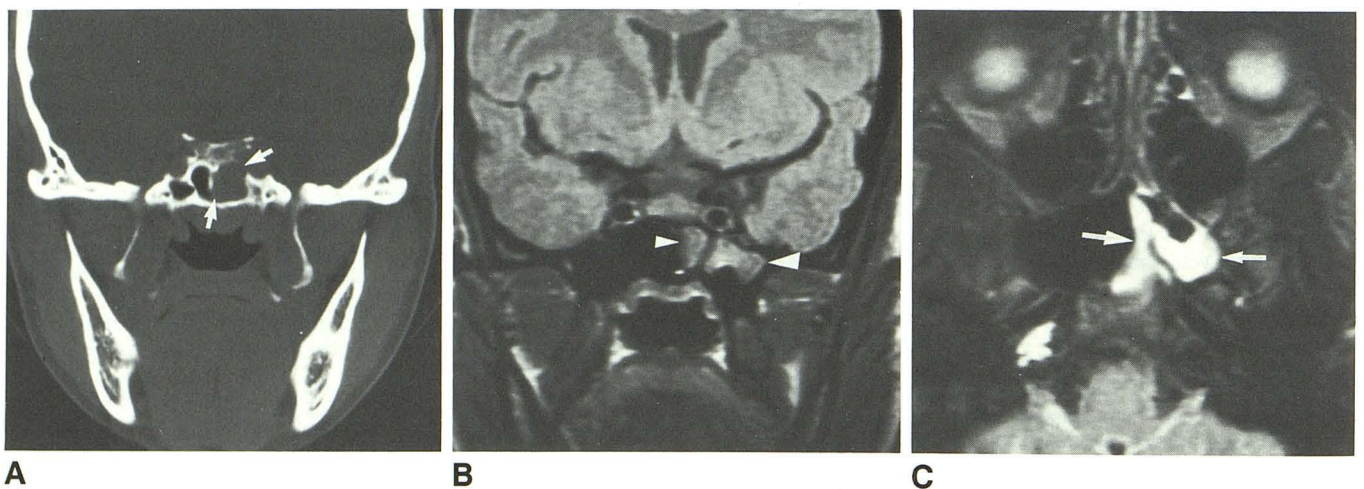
A, Coronal CT scan with bone windows shows destruction of left superolateral wall and septum of sphenoid sinus (*arrows*) by soft-tissue mass.
